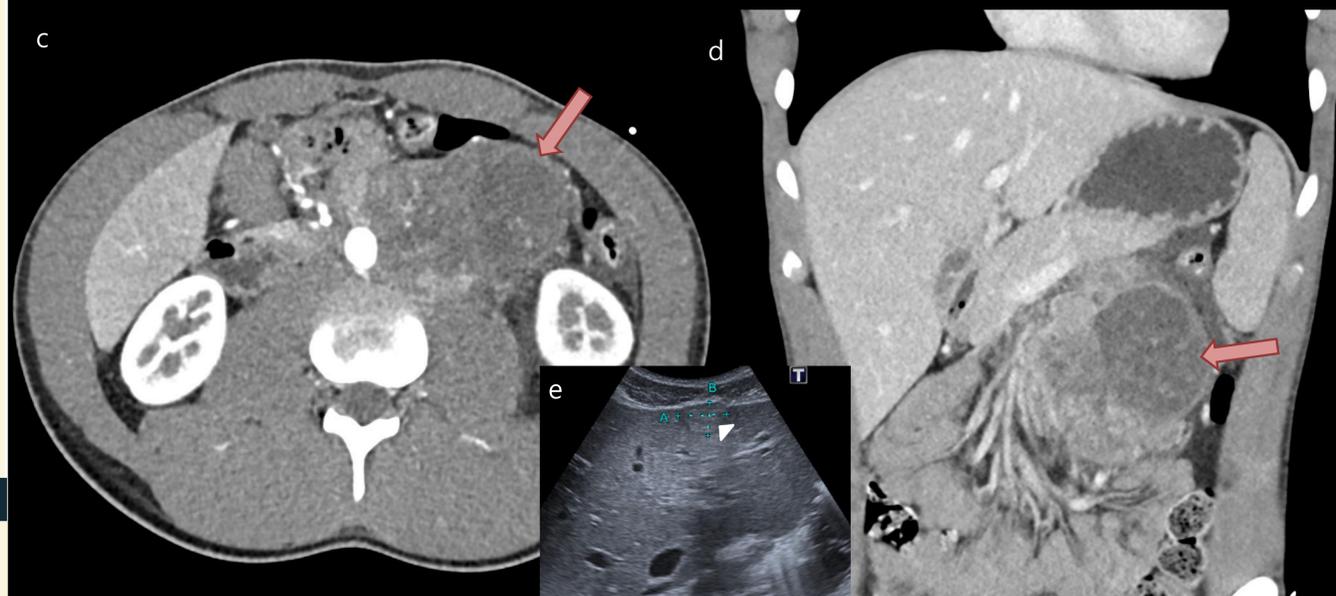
(c-d): Contrast-enhanced CT scan of the abdomen in venous phase axial (c) and coronal (d) views revealing a large heterogenous retroperitoneal tumor (red arrows) with central necrosis, signs of neovascularization, invasion of left renal vein and of a spinal vein, and an abdominal ultrasound (e) showing a subcapsular isoechoic oval-shaped lesion with hypoechoic halo (white arrowhead) - liver metastasis
